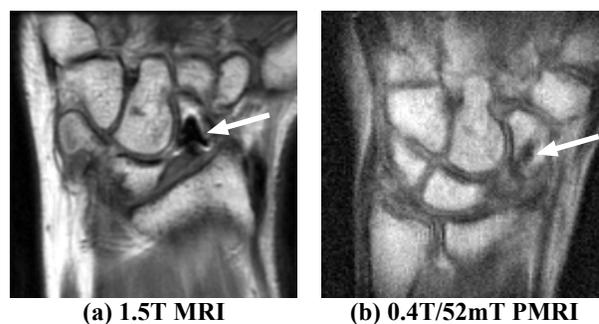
Comparison coronal wrist images of a volunteer with a scaphoid screw (arrows). Metal susceptibility artifacts are greatly reduced in PMRI (b) compared to 1.5 T MRI (a) using 3D RARE/FSE. Scan times were (a) 6.5 and (b) 4.5 min; resolution and gradient amplitudes were matched.
